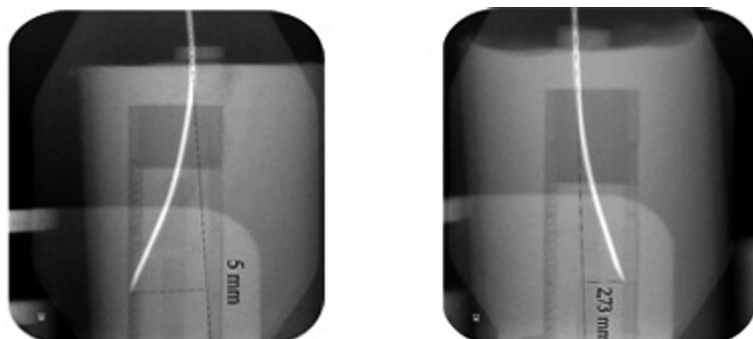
Radiographs, showing the deflection in the hydrocolloid cylinder
